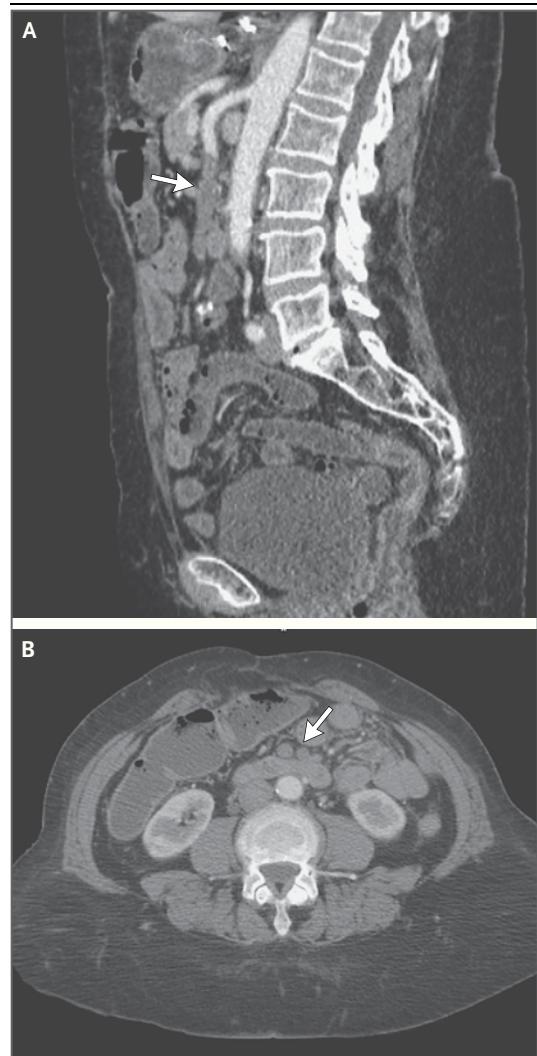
Computed Tomographic Angiography (CTA) in a Patient with Acute Mesenteric Ischemia Caused by an Embolism in the Superior Mesenteric Artery.
